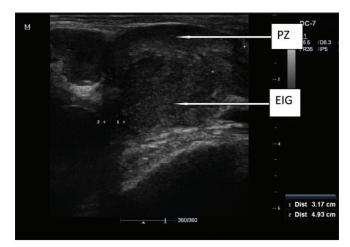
Transrectal sonogram (midsagittal section) of benign prostatic enlargement showing the slightly compressed peripheral zone by an enlarged inner gland (EIG, Enlarged Inner Gland = central zone + transitional zone). Line 1: Superoinferior diameter of the enlarged transitional zone; Line 2: Superoinferior diameter of the enlarged whole prostate
